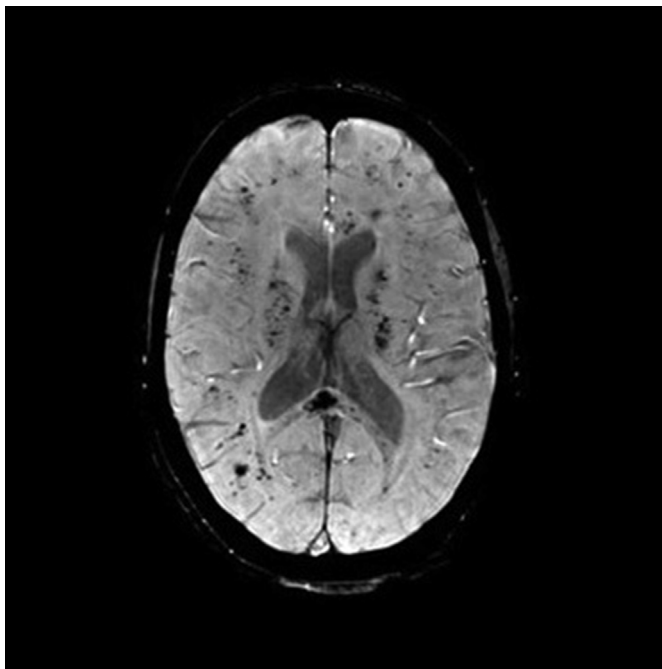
MRI-SWI of the same patient as Fig 6 showing multiple and profuse small foci of low intensity, essentially involving the white matter, representing microhaemorrhages due to fat embolisation (“walnut kernel pattern”).
